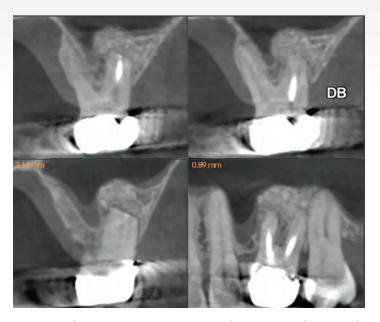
The one-year post-operative cone beam computed tomography (CBCT) scan showed complete regeneration of the defect and buccal plate
